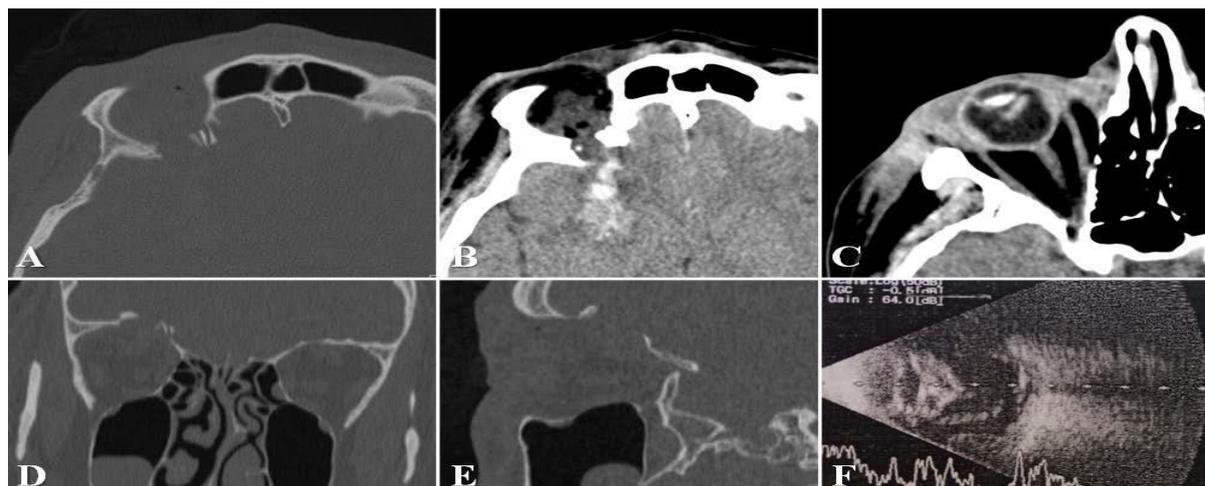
Fracture in the right orbital roof (CT-Scan) (A, B, D, E). Vitreous hemorrhage and choroidal hematoma (right eyeball) (C). Retinal detachment with vitreous hemorrhage and choroidal hematoma (ocular ultrasound) (F) (Turliuc *et al.*, 2017a).
